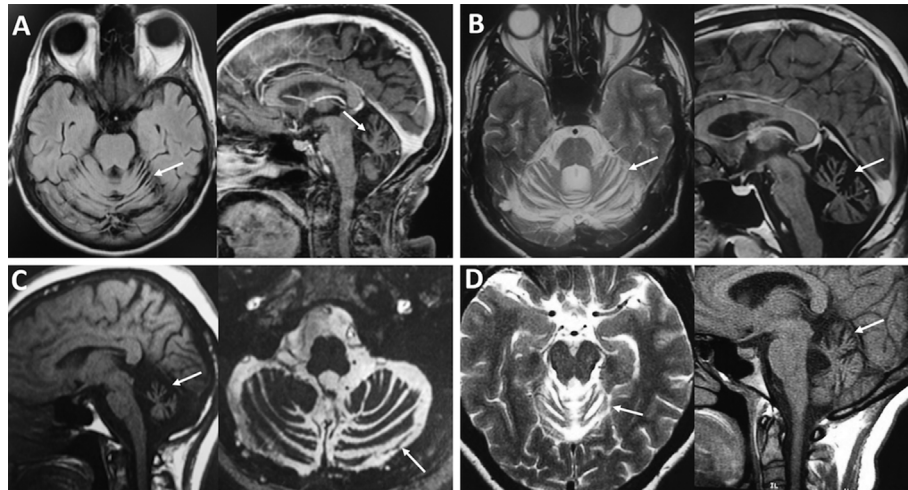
A) *Patient 1:* Axial FLAIR-weighted and sagittal T1 brain MRI show global cerebellar atrophy (white arrows). B) *Patient 2:* Axial T2-weighted and sagittal T1 MRI demonstrate cerebellar and brainstem atrophy (white arrows). C) *Patient 3:* Sagittal T1 and T2-weighted MRI demonstrate cerebellar and brainstem atrophy (white arrows). D) *Patient 4:* Axial T2-weighted and sagittal T1 MRI disclose pure cerebellar atrophy (white arrows).
